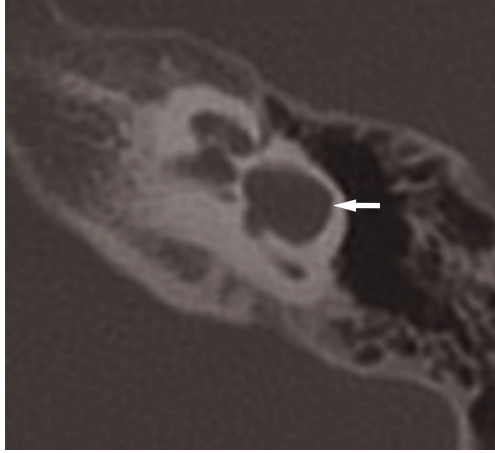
Axial CT scan. Cystic lateral semicircular canal confluent with the vestibule (arrow).
